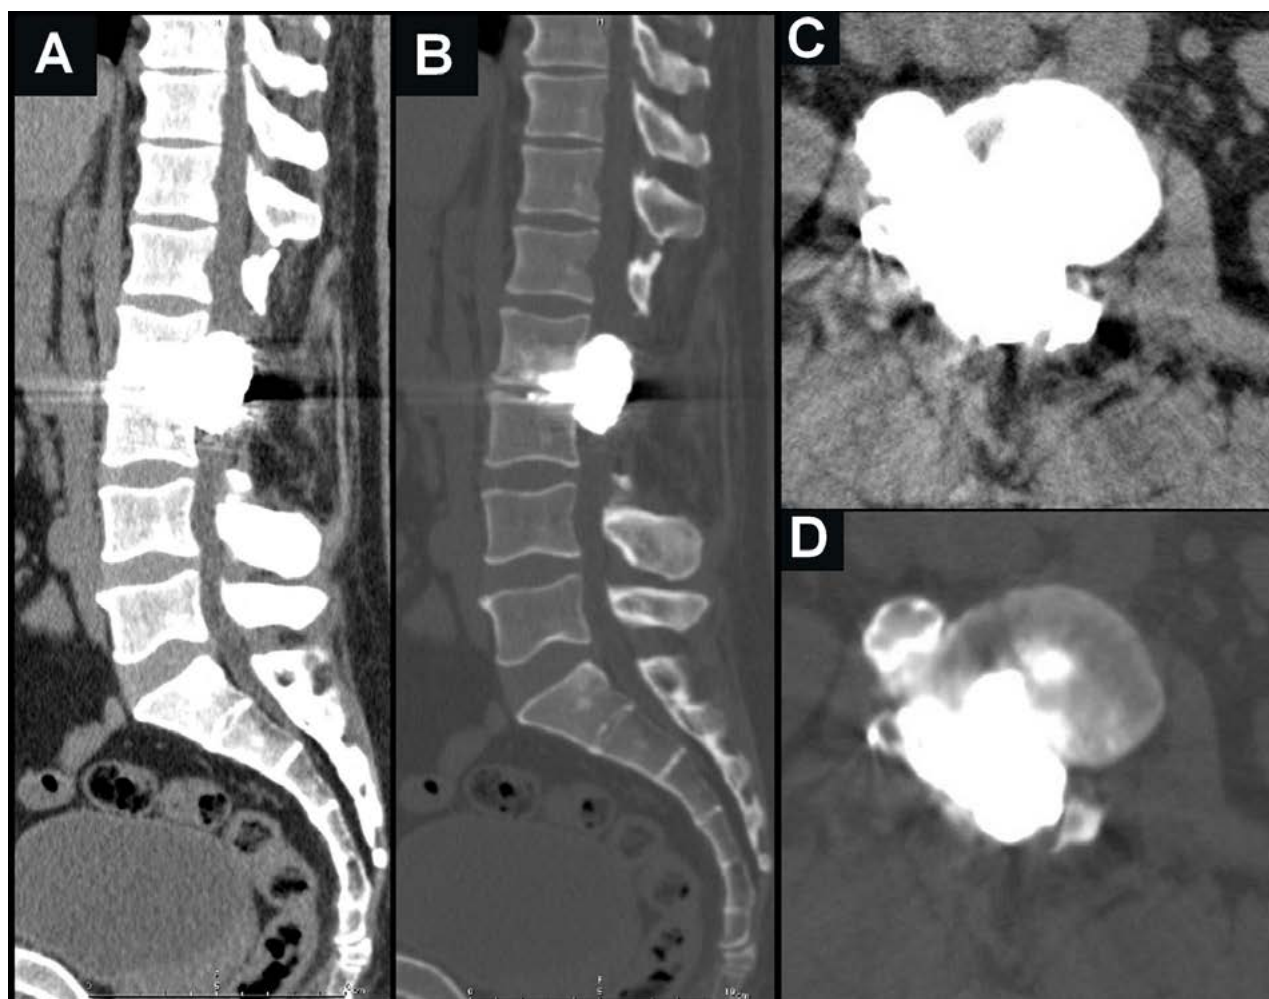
CT of the lumbar spine (A,B,C,D) characterizing a large irregular material with metal density occupying most of the spinal canal and disc space at L2-L3.
